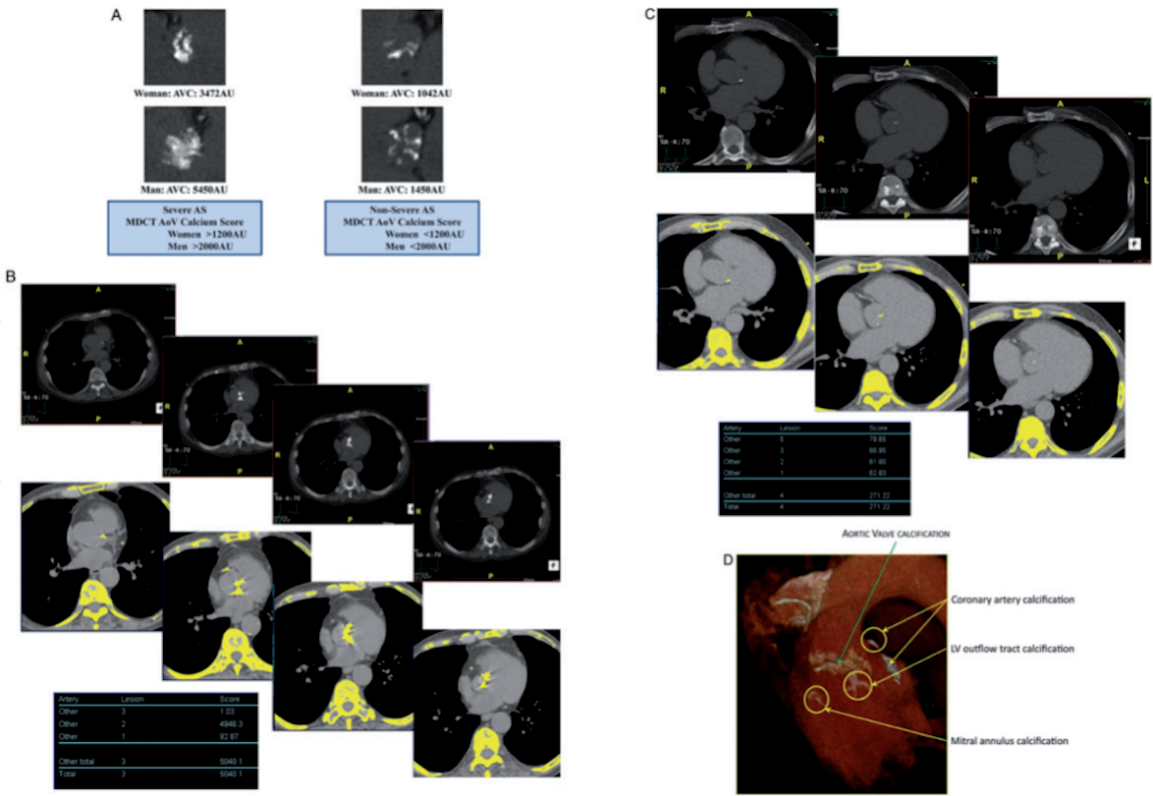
Quantitation of aortic valve calcium by multi-detector computed tomography for the assessment of stenosis severity in low-gradient aortic stenosis. (A) Multi-detector computed tomography can be used to quantitate aortic valve calcification by the modified Agatston method. With this method, calcification is defined as four adjacent pixels with density 0.130 Hounsfield units. Different cut-point values of valve calcium score should be used in women (0.1200 AU) versus men (0.2000 AU) to differentiate true-severe versus pseudo-severe stenosis in low-flow, low-gradient aortic stenosis. (B) Serial multi-detector computed tomography slices at the level of the aortic valve showing a severely calcified valve with a calcium score of 5040 AU consistent with true-severe aortic stenosis. Calcified areas are displayed in yellow in the bottom images. (C) Mild calcification (score 271 AU) consistent with pseudo-severe aortic stenosis. (D) Pitfalls in the assessment of aortic valve calcification by multi-detector computed tomography. For the calculation of calcium score, it is important to only include aortic valve calcification and exclude calcification of aorta, coronary arteries, LVOT, and mitral annulus. Adapted with permission from Clavel et al. [32].
